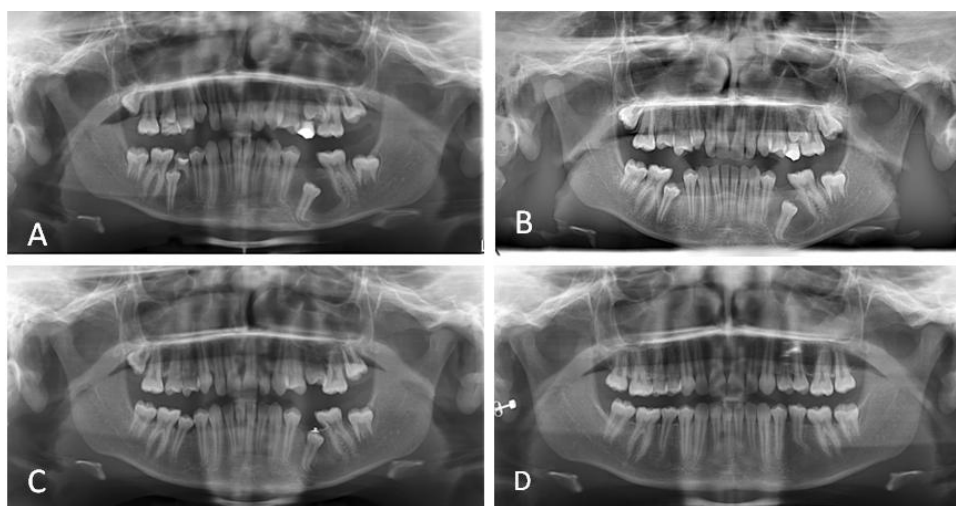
A) Panoramic radiograph 1 month after marsupialization; B) 2 month after marsupialization; C) after orthodontic traction with removable appliance; D) Panoramic radiograph after fixed orthodontic treatment.
